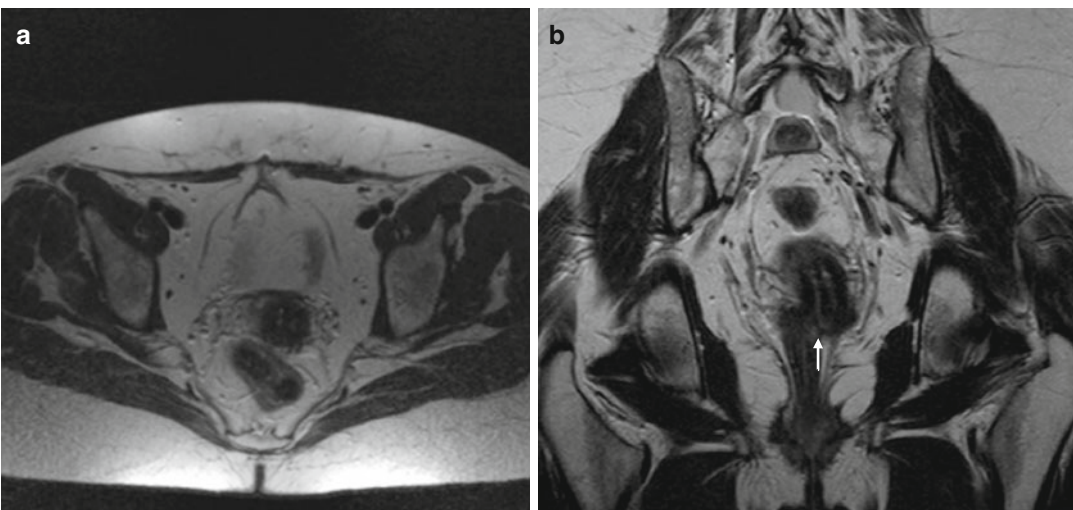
Complete bicornuate uterus (IVa). Fast spin-echo T2-weighted images on axial (TR 2800/TE 110) (a) and coronal plane (TR/TE 4070/94) (b) demonstrate two
